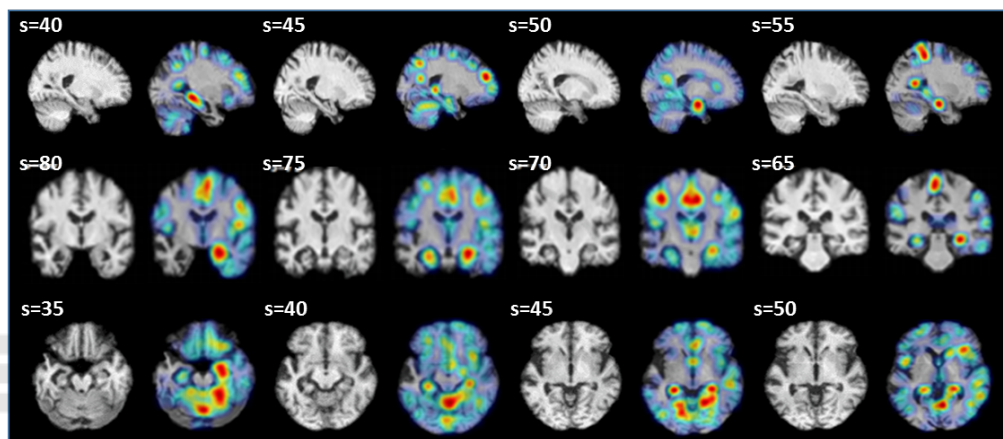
MRI slices selection of AD subject (the subject is 80 years old with an MMSE equal to 25).
